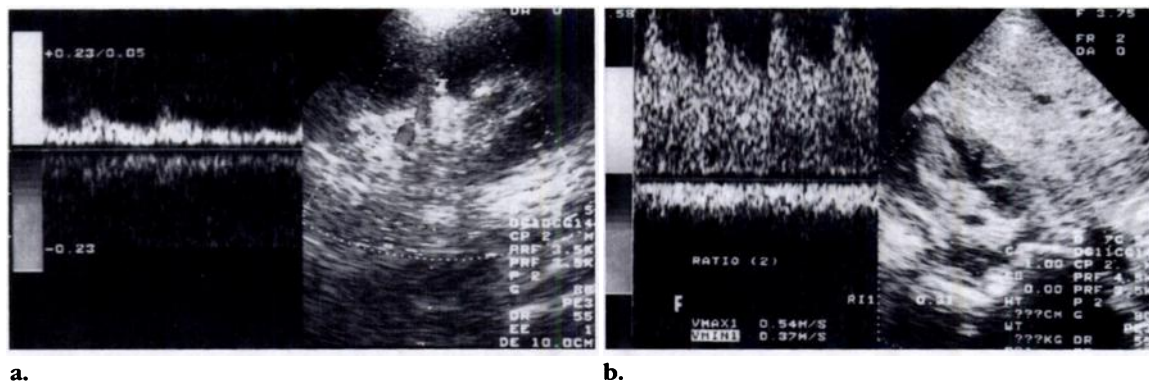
Polyarteritis nodosa. (a, b) Doppler spectrum (left) and sonogram (right) of the segmental and interlobar arteries of the right kidney show inhomogeneous hemodynamic alterations including a severe tardus-parvus waveform (a) and accelerated low-resistance flow (b). Microaneurysms were not visible on the color Doppler sonograms. (c) Selective angiogram of the right kidney demonstrates multiple aneurysms of the interlobar arteries, characteristic of a necrotizing arteritis. Also note the inhomogeneity of cortical perfusion, with prominent capsular arteries supplying small branches to the renal cortex (arrows).
